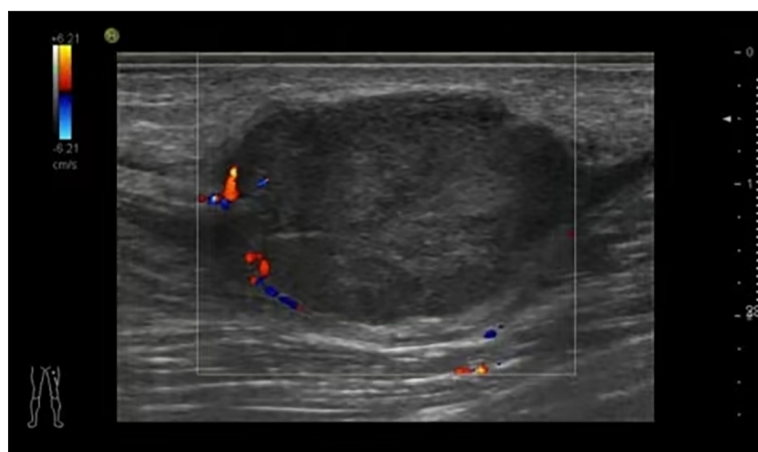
Ultrasound image of the mass in the left thigh.
